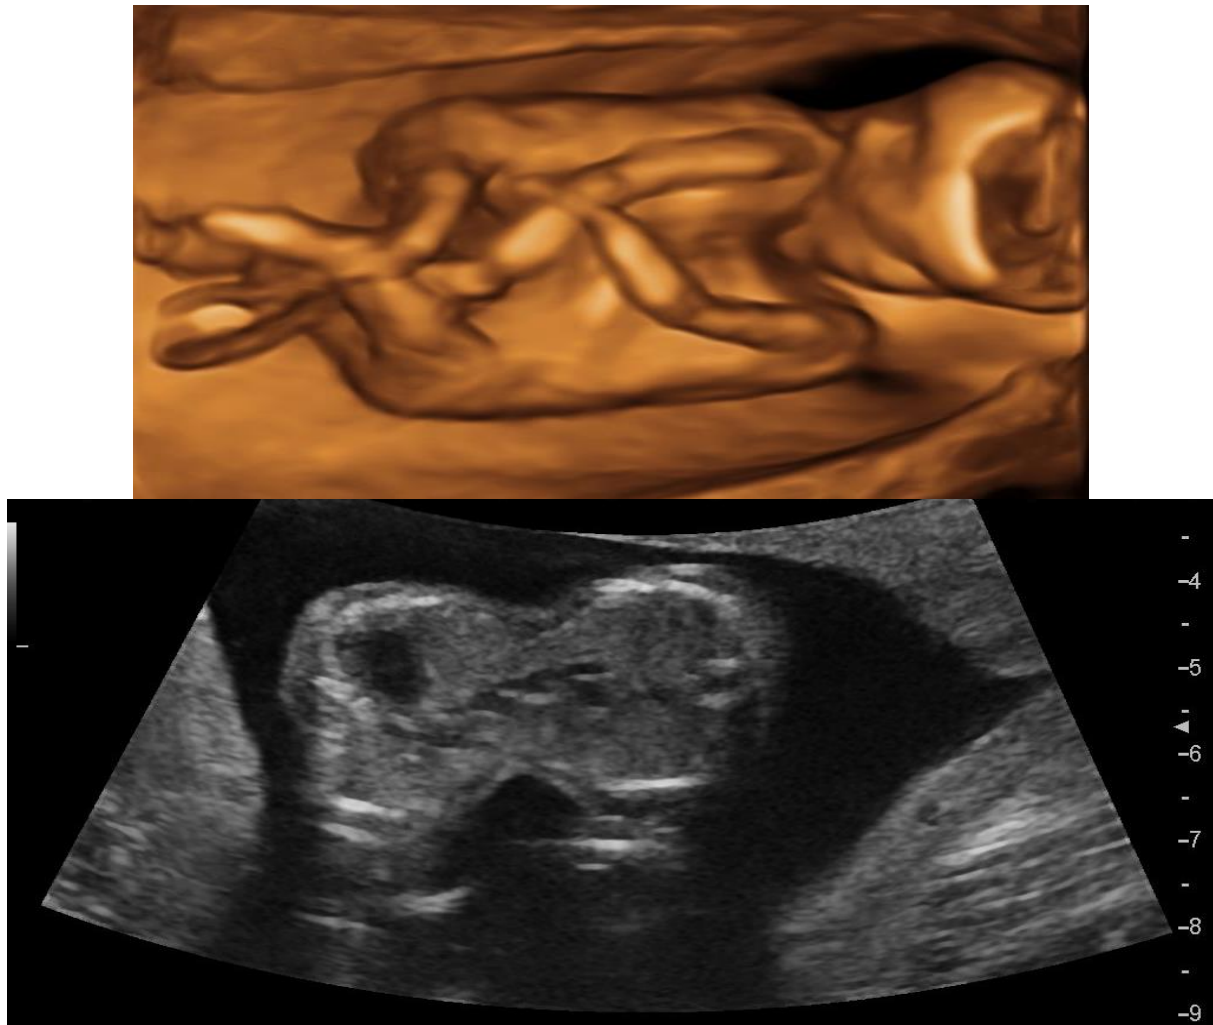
ultrasound image of a conjoined twin
